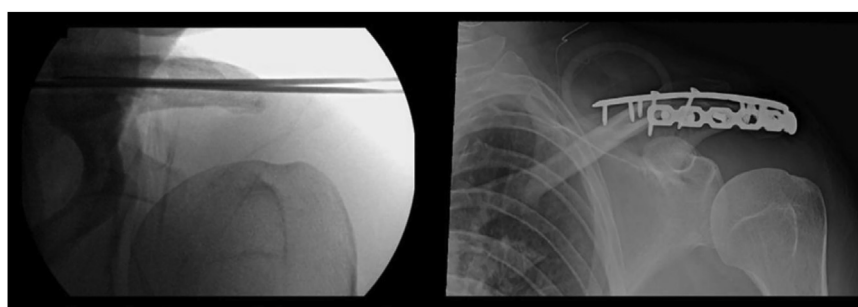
Intraoperative fluoroscopic image demonstrating fracture reduction and temporary fixation with 2 Kirshner wires and single-view postoperative radiograph demonstrating final fixation construct.
